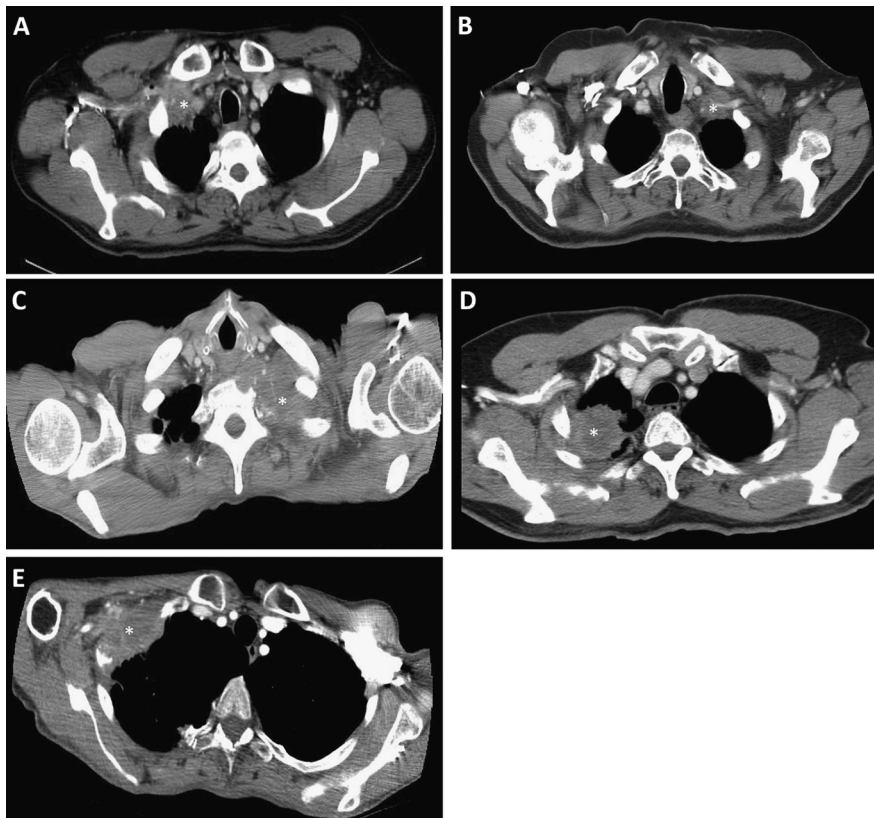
Computed tomographic images depicting tumor involvement of the 5 different zones of the thoracic inlet: (A) zone 1, (B) zone 2, (C) zone 3, (D) zone 4, and (E) zone 5. Tumors are indicated by asterisk.
